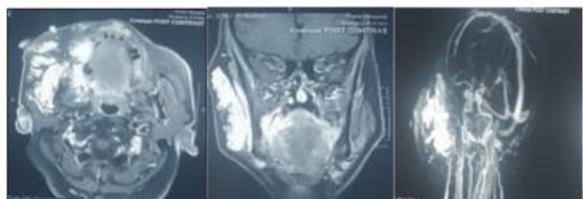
T2 weighted images show hyperintensity diffuse margins. T1-weighted sequences demonstrate hyperintensity in post-contrast T1-weighted sequences as a result of intralesional pooling of contrast agent.
